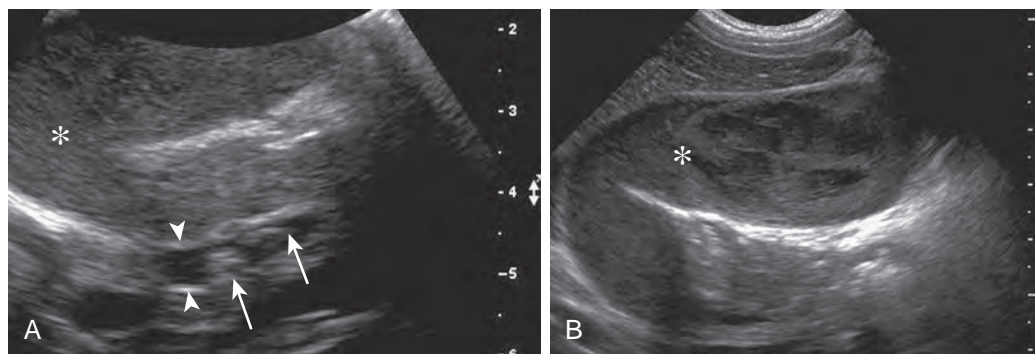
Common bile duct stone or sludge: sonographic features. A. The common bile duct (arrowheads) is abnormally dilated and contains hyperechoic stones, sludge, or both (arrows). B. The gallbladder is grossly distended with sludge (asterisk) in this 8-year-old child with sickle cell disease.
